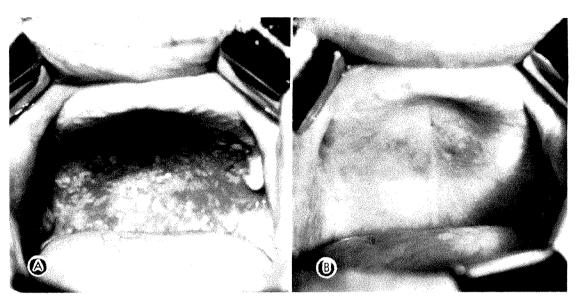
Carcinoma of the hard palate. Treatment was given in 1941 with 400 kv. roentgen rays plus intra-oral cone. (A) Pretreatment. (B) Four months post treatment. The lesion remained healed until death in 1946.
